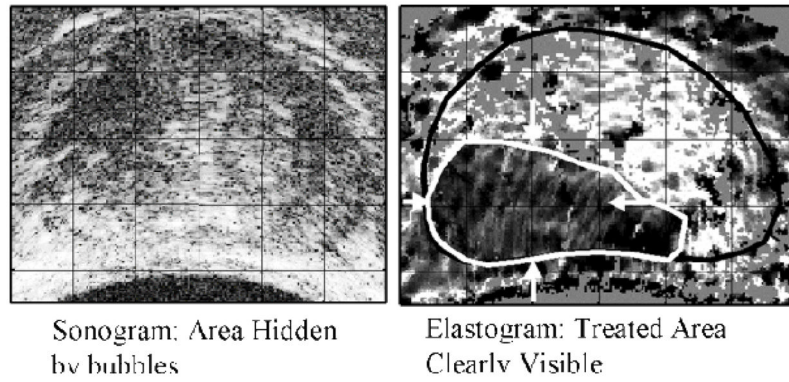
Prostate sonogram (left image) showing somewhat increased echogenicity due to bubble formation during HIFU. Elastogram on right shows the ablated area as a clear dark (stiff) region. Images courtesy of Remi Souchon.
